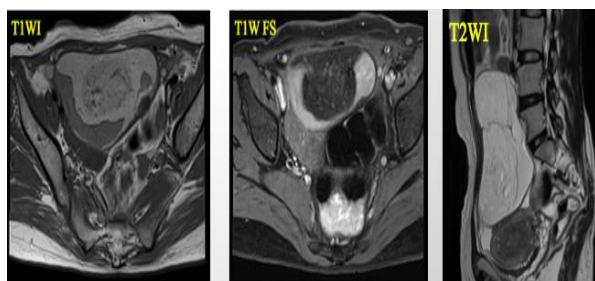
A 27 year old patient presented with vague abdominal pain and vomiting. MRI shows, the lesion to be hyperintense on both T1W and T2W images, which gets suppressed on T1W Fat saturated images, along with the presence of surrounding hyperintense free fluid. - Ruptured Dermoid Ovarian Cyst
